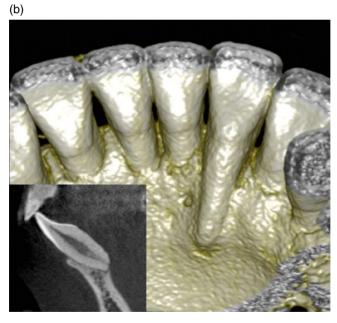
(a) Another example of unexpected tooth movement during the retention period, arising again from increased root lingual torque of the lateral incisor. (b) cone-beam computed tomography (CBCT) images.
